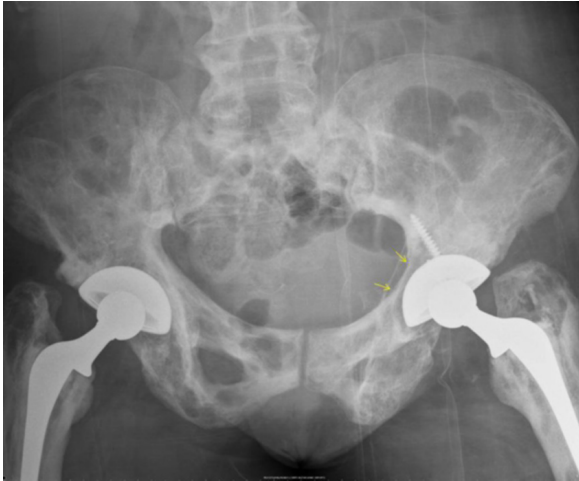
53-year-old woman with bone tumor arising in Paget disease. AP radiograph of the pelvis shows Paget disease and bilateral total hip arthroplasty. On the left (arrows) there is destruction of the posteromedial wall of the acetabulum. Additional findings include spinal decompression with laminectomy at L4 and L5 and diffusely enlarged pagetoid bone with cortical and trabecular coarsening.
